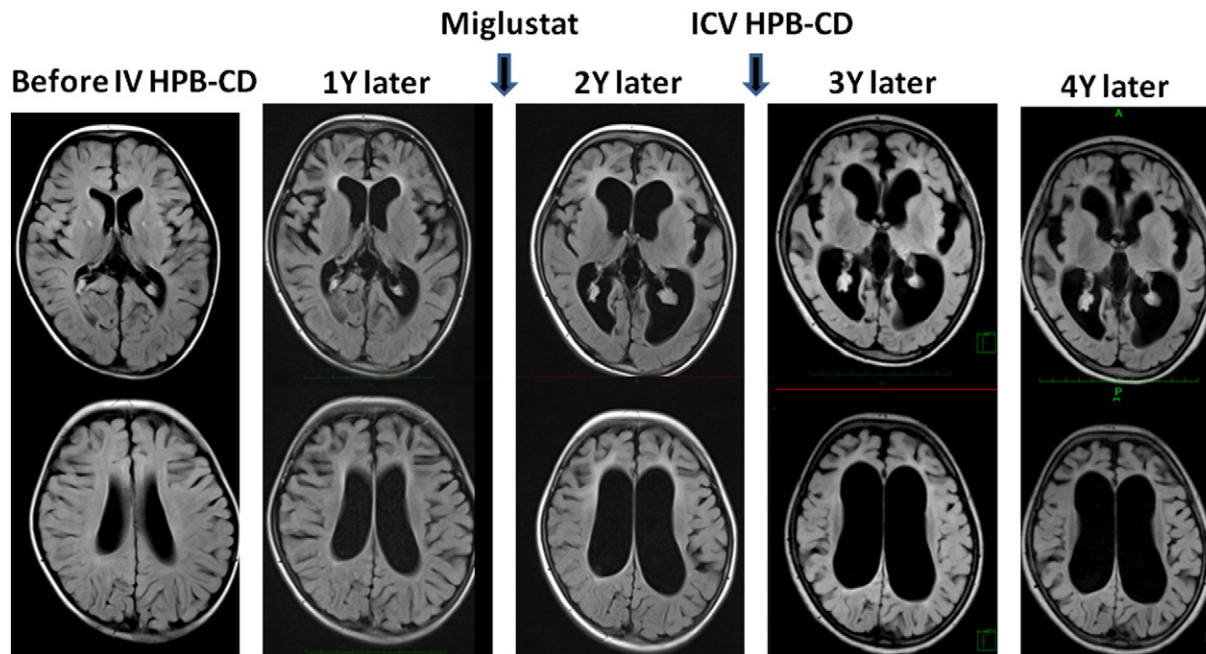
Changes in MRI (FLAIR, fluid attenuated inversion recovery, images) before and after treatment with 2-hydroxypropyl- β -cyclodextrin. Miglustat was added after 1 year of treatment. Progressive brain atrophy is visible especially before the ICV HPB-CD therapy.
